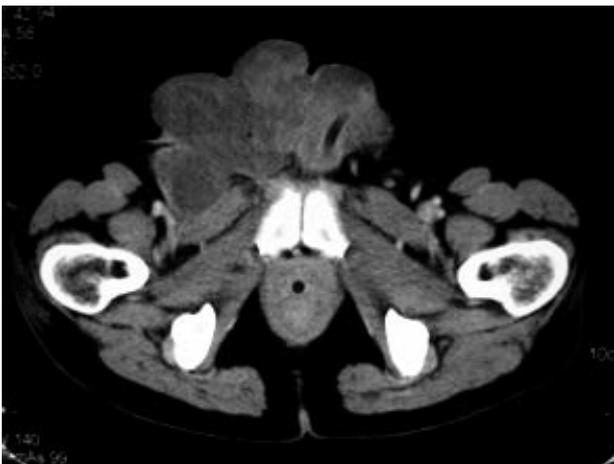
Pelvic CT scan prior to diagnosis.
